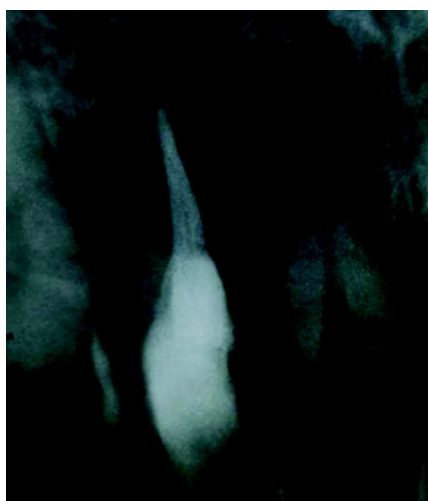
Three months follow-up radiograph
